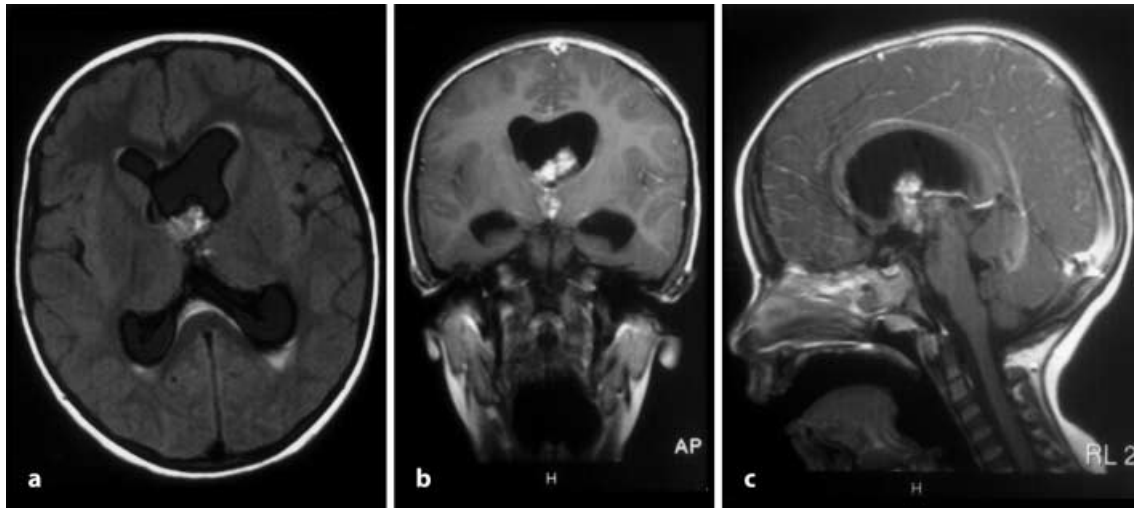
T1 contrast-enhanced a axial, b coronal and c sagittal MRI sequences showing the tumour prolapsing from the lateral ventricle, through the Foramen of Monro into the third ventricle
